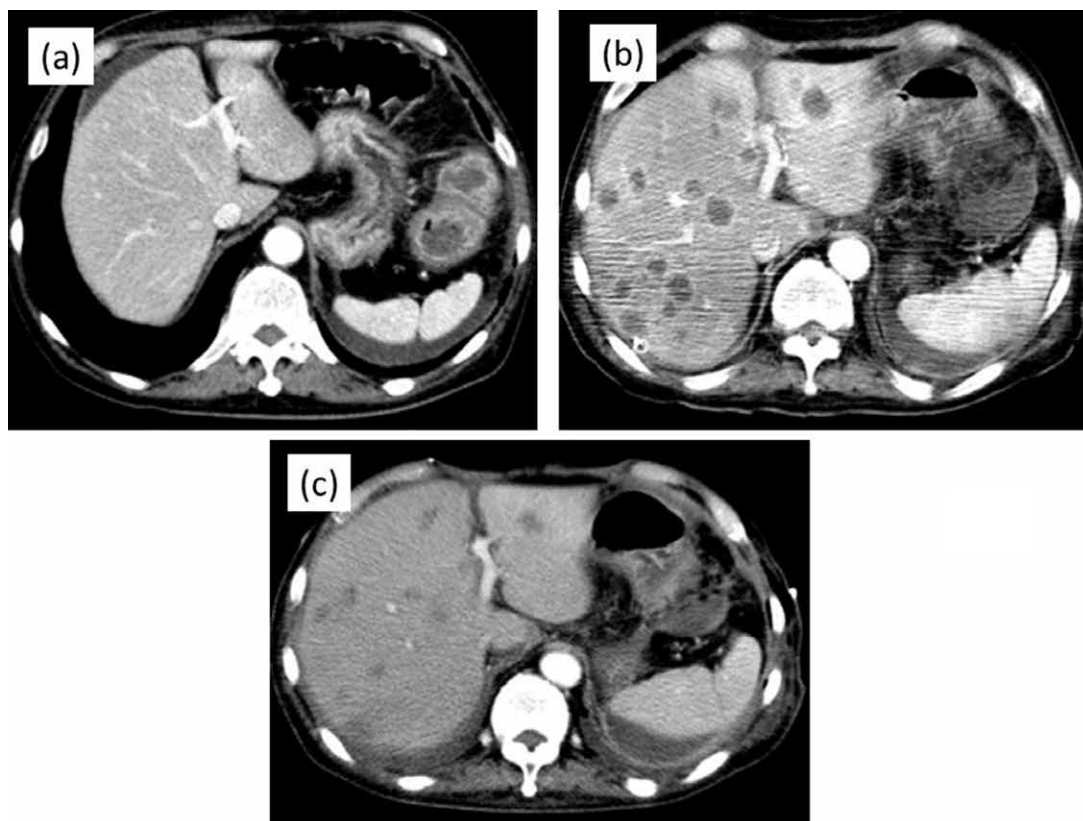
Abdominal enhanced computed tomography
